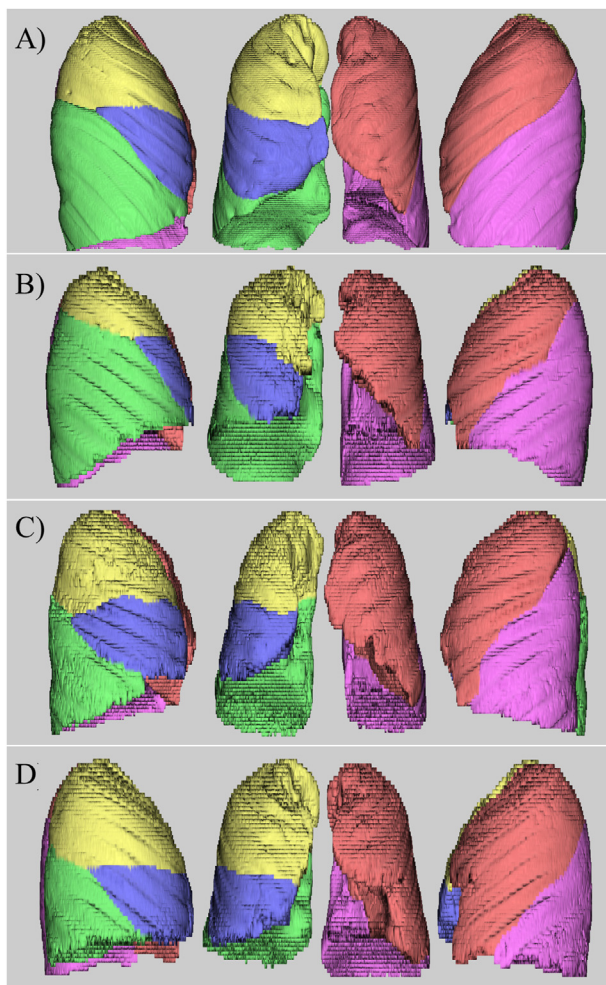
Three-dimensional computed tomography of the lung images obtained at diagnosis.
